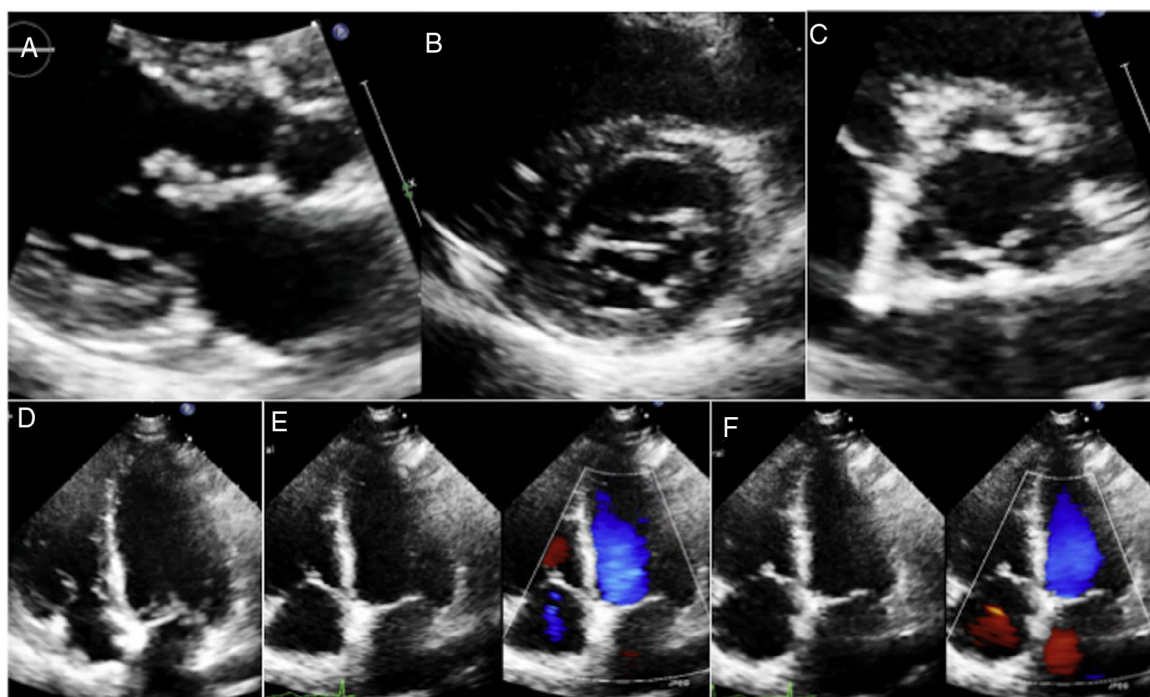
Transthoracic bidimensional echocardiographic study with nodular thickening in subvalvular apparatus and mitral valve leaflet (A,B), aortic valve (C) and tricuspid valve (D,E). Mild tricuspid regurgitation was found with color flow (E,F).
